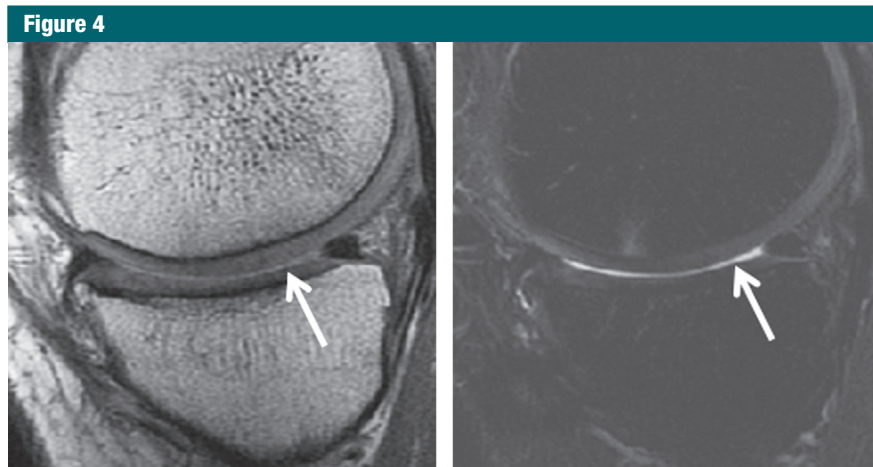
Images in 36-year-old man with surgically confirmed grade 1B cartilage lesion on lateral femoral condyle (classified as MR grade 1A cartilage lesion). (a) Sagittal intermediate-weighted fast spin-echo image and (b) sagittal fat-suppressed T2-weighted fast spin-echo image show normal-appearing articular cartilage on lateral femoral condyle (arrow). (c) Corresponding sagittal T2 map shows area of increased T2 relaxation time on lateral femoral condyle (arrow).
